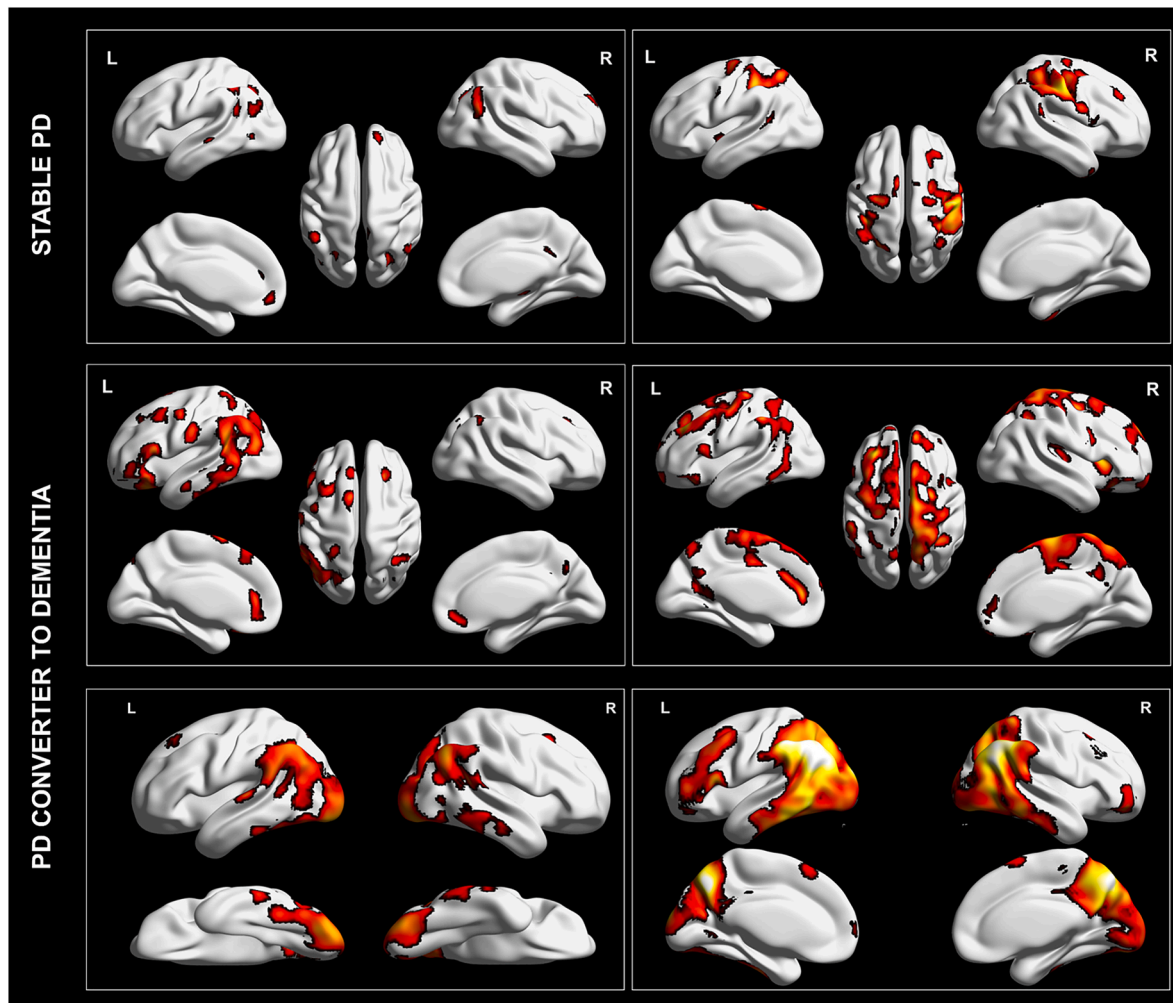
Examples of typical and atypical statistical parametric mapping of brain FDG-PET patterns at baseline in single PD cases.
